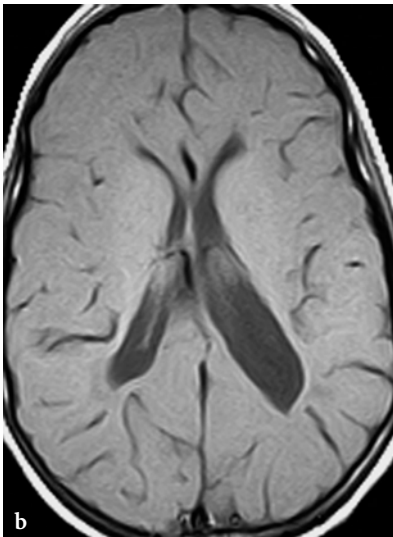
Conventional MR imaging findings in a 9-year-old male patient with *Salla* disease (courtesy of Dr. P. Tortori-Donati, Genoa, Italy). a Sagittal T1-weighted spin-echo image, showing hypoplasia of corpus callosum and atrophy of the cerebellar vermis. b, c Axial T1- and T2-weighted spin-echo images. Moderate ventricular enlargement and diffuse paucity of myelin within the cerebral hemispheres. d. Coronal T2-weighted fast spin-echo image. Extensive white matter disease within the cerebral hemispheres
